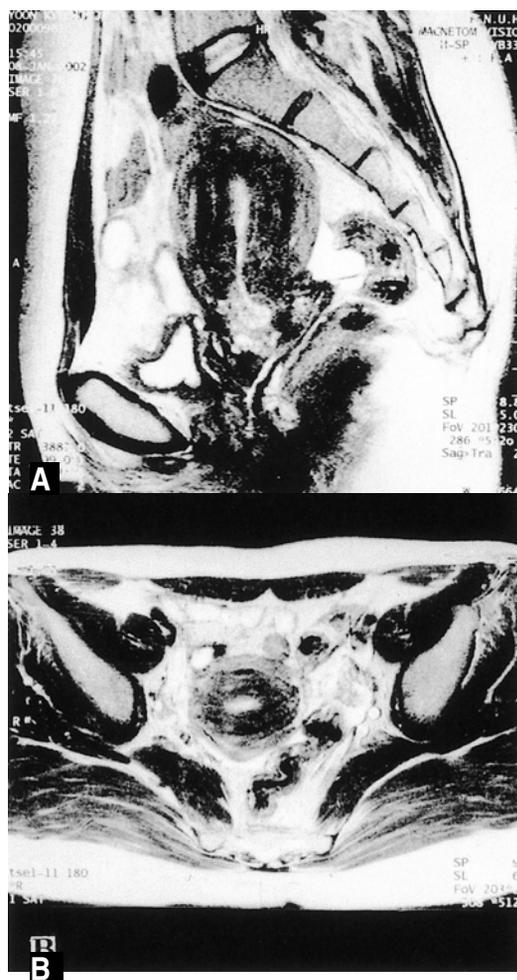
MRI finding, A) & B): Mass lesion was not exceeding the cervix and both ovaries look normal. There were no enlarged pelvic lymph nodes.
